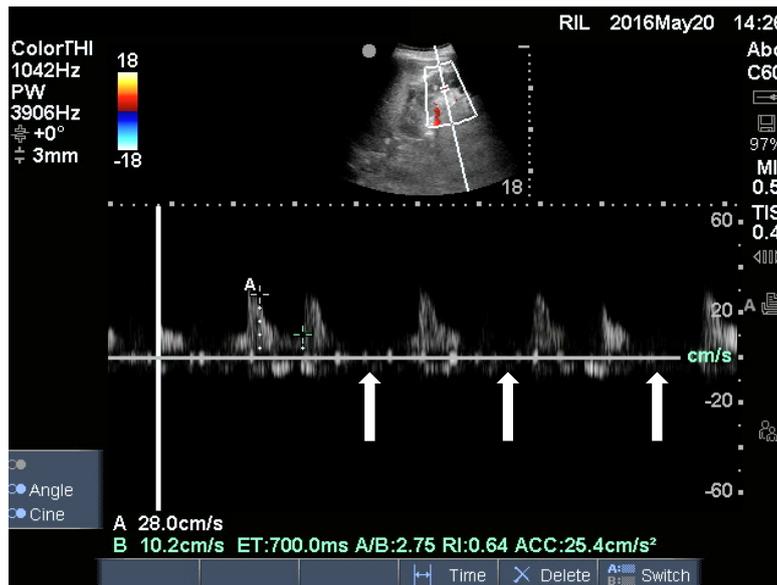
Doppler sample gate moves in and out of the vessel lumen with movement of the kidney during breathing motion. This results in loss of the Doppler signal and gaps within the spectra trace (bold arrows).
